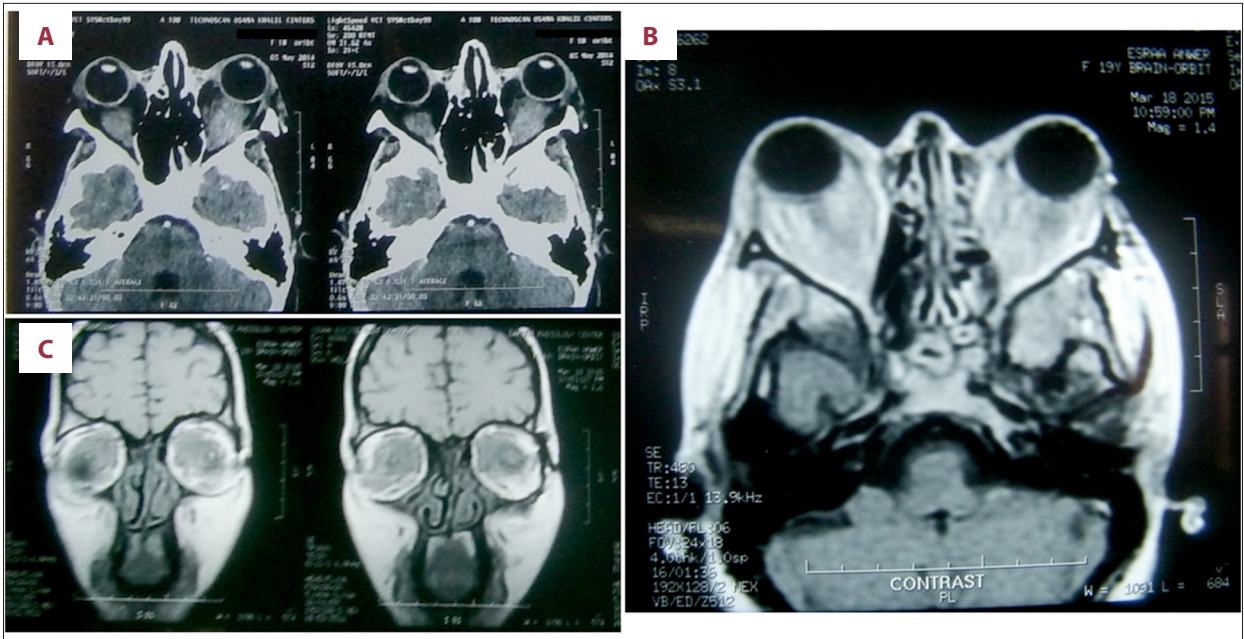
(A) CECT scan of both orbits showed bilateral infiltrations in and around both optic nerves and bilateral exophthalmos. (B, C) Enhanced axial and coronal T1-weighted demonstrating bilateral low-signal intensity lesions in the intraconal and extraconal spaces, and anterior to the orbital septum with significant heterogenous enhancement after contrast administration.
